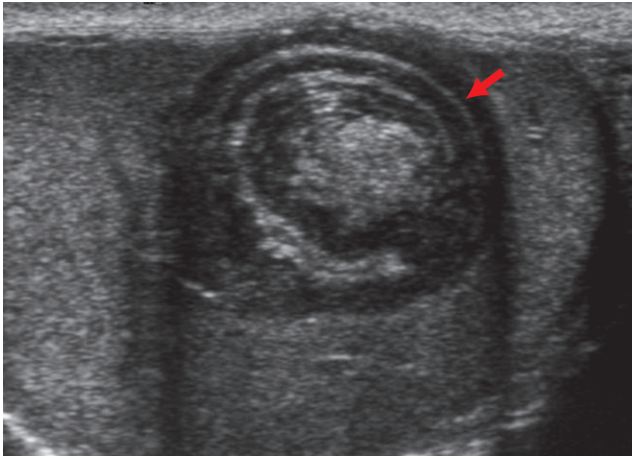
The longitudinal sonographic image of the testis shows a solid lesion with alternating hyperechoic and hypoechoic concentric rings (arrow) with an echogenic center.
